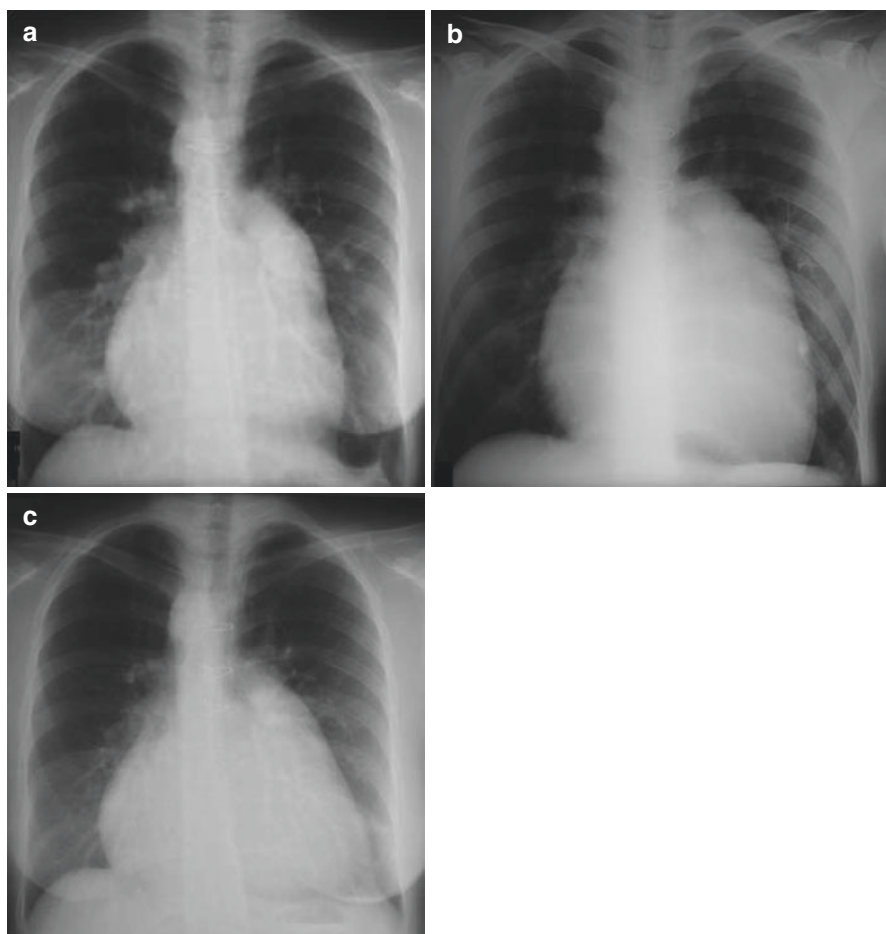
A woman with repaired tetralogy of Fallot in whom pregnancy had an impact on the progression of enlarged right heart. She had severe pulmonary regurgitation and atrial tachycardia before pregnancy. Her chest X-ray showed more enlarged heart after pregnancy (a, before pregnancy; b, right before delivery; c, 1 year after delivery)
